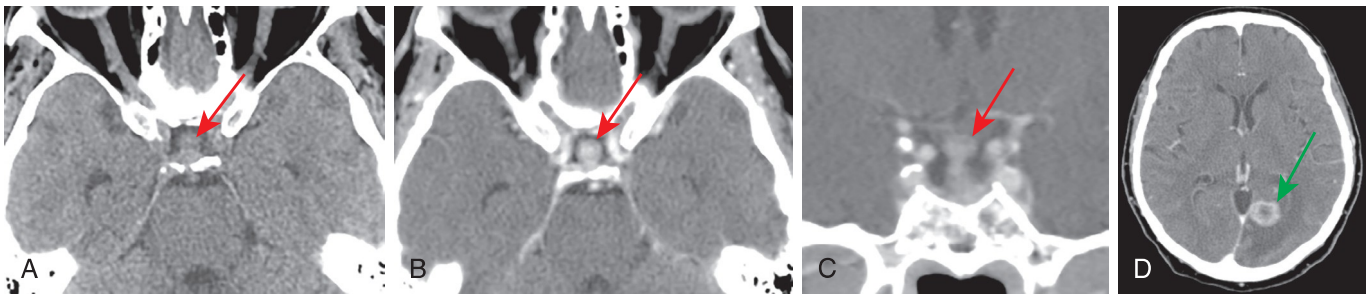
Metastasis. A 74-year-old woman with a history of breast carcinoma presenting with vertigo. (A) Noncontrast axial computed tomography (CT) demonstrates a hyperdense suprasellar lesion (*red arrow*) and edema in the left occipital lobe (not included). (B and C) Postcontrast axial and coronal CT demonstrate homogeneous enhancement of the suprasellar lesion (*red arrows*), which involves the pituitary stalk. (D) Postcontrast axial CT demonstrates a rim-enhancing lesion in the left occipital lobe (*green arrow*) consistent with metastatic disease.
